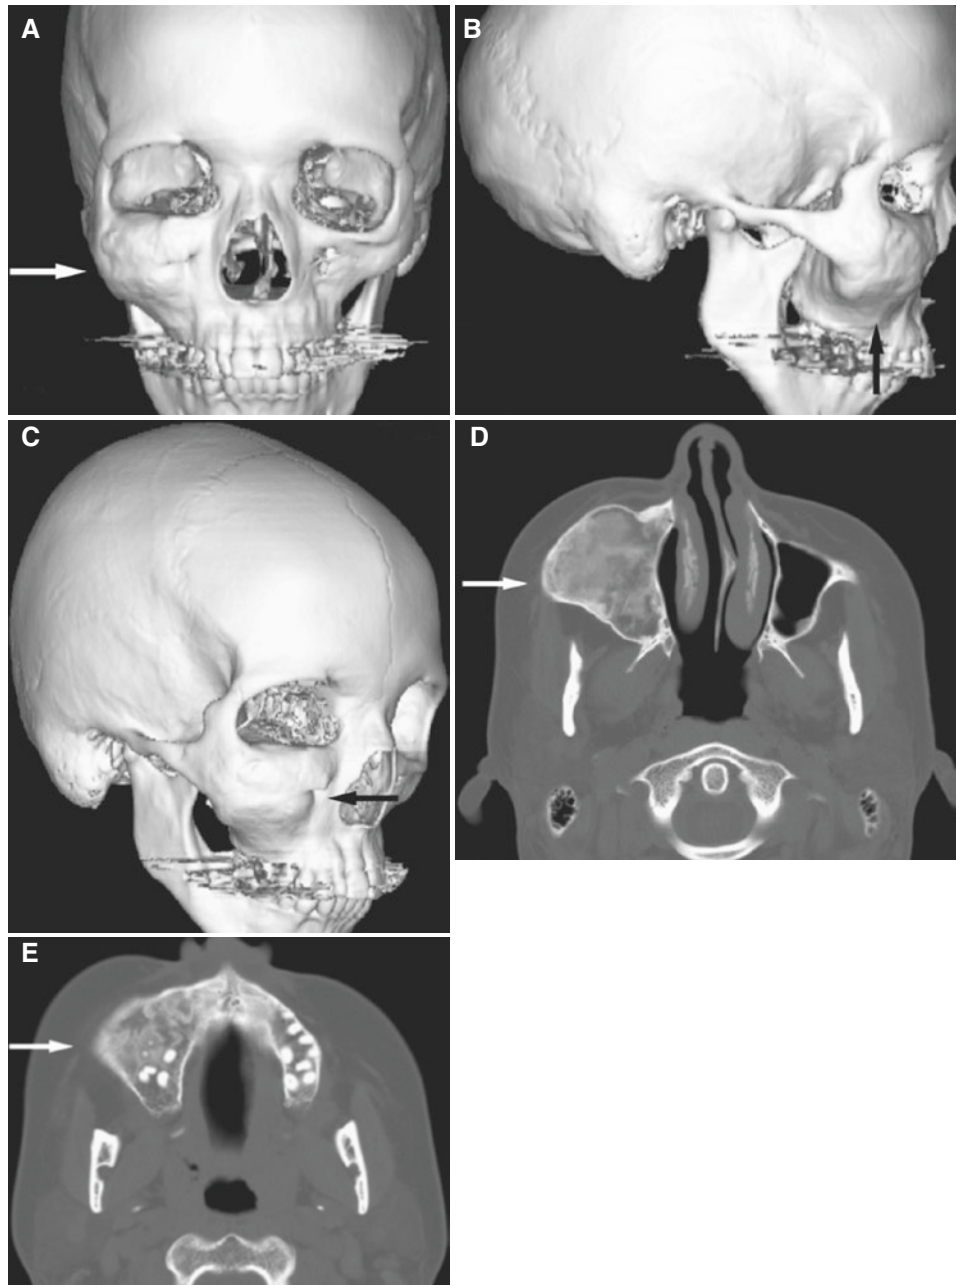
Fibrous dysplasia; 23-year-old female with painless swelling of cheek. (A) 3D CT image, en face, shows the expanded right maxilla and zygoma (*arrow*) with elevated orbital floor. (B) 3D CT image, lateral, shows the expanded frontal process and anterior wall of the maxilla (*arrow*). (C) 3D CT image, oblique view, shows the elevated
